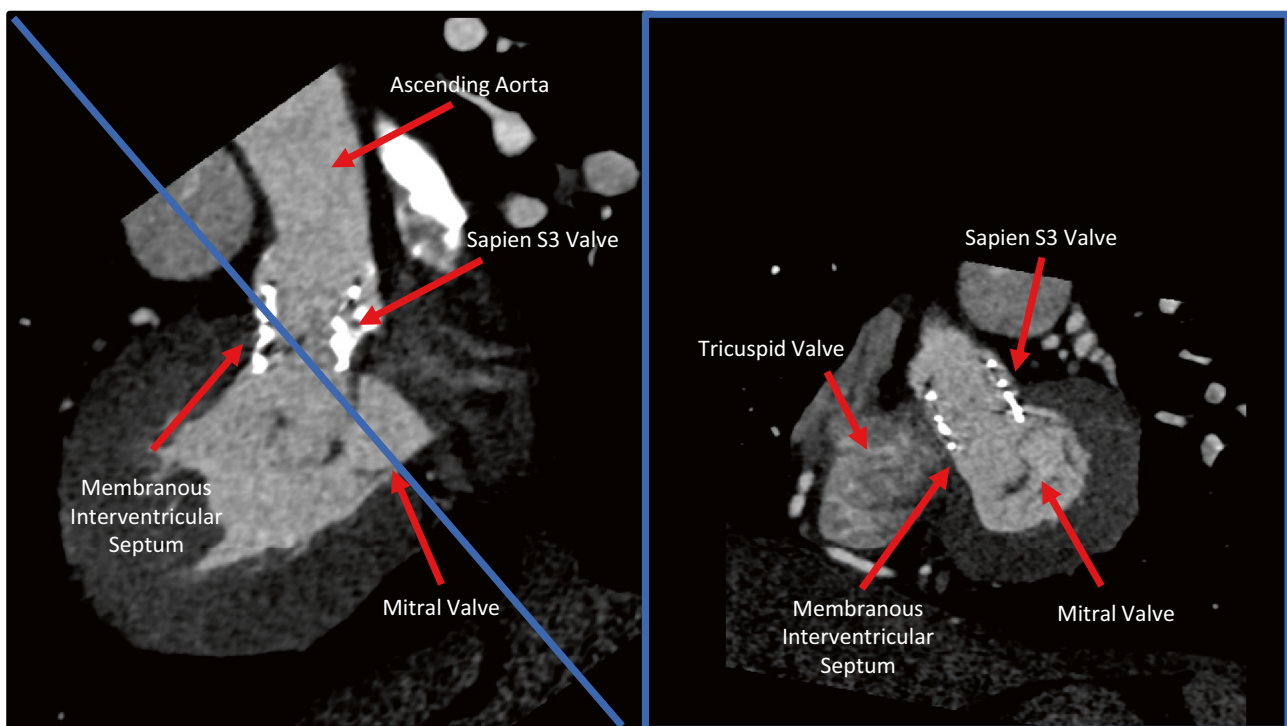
Cardiac CT scan showing the position of a Sapien S3 TAVR valve relative to the ascending aorta, left ventricular outflow tract, and membranous interventricular septum in longitudinal (left panel)
